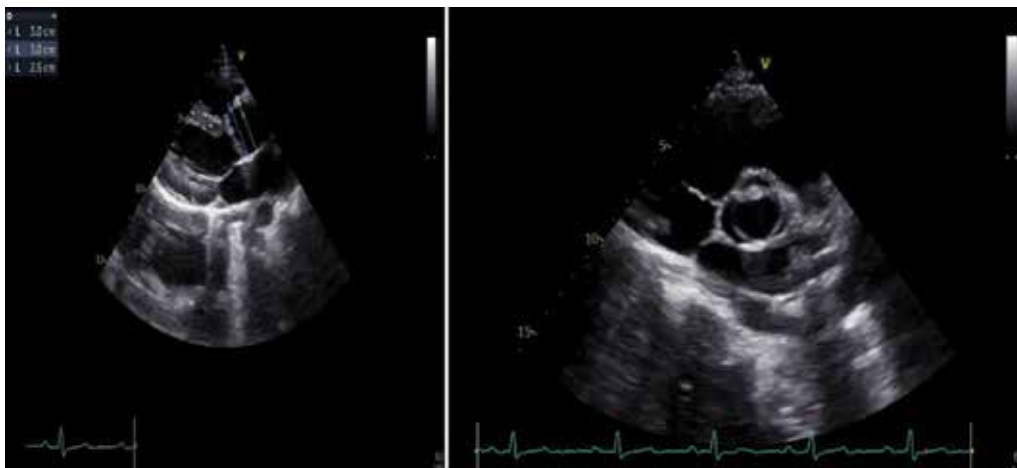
The parasternal long and short axis view showed an unicuspid aortic valve.
